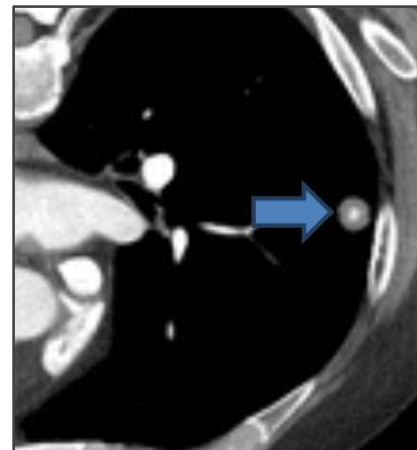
CT Showing Bulls Eye Pattern of Calcification
